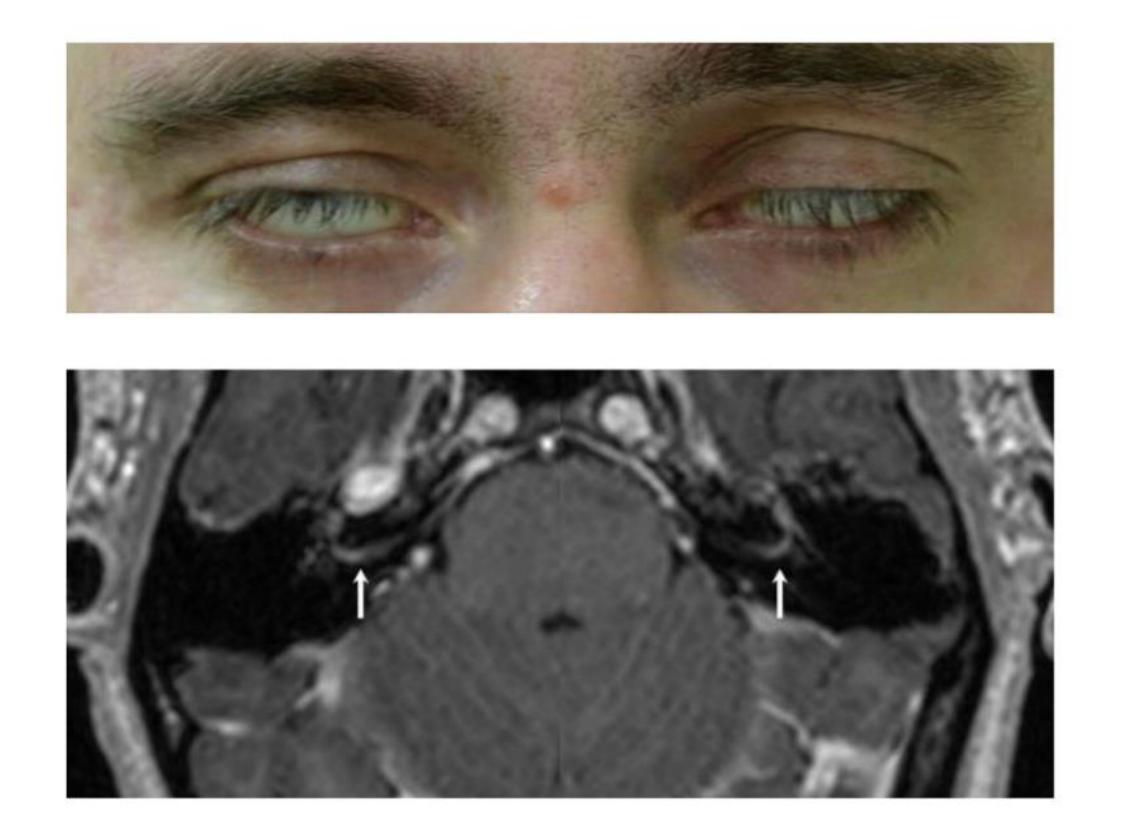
A. Bilateral Bell's palsy with inability for complete eyelid closure (bilateral lagophtalmus). B. After intravenous gadolinium administration, bilateral strong enhancement of the facial nerve in its extra- and intracanalicular segments is visible (white arrows), axial T1-weighted gradient echo sequence (reproduced with permission from [33]).
